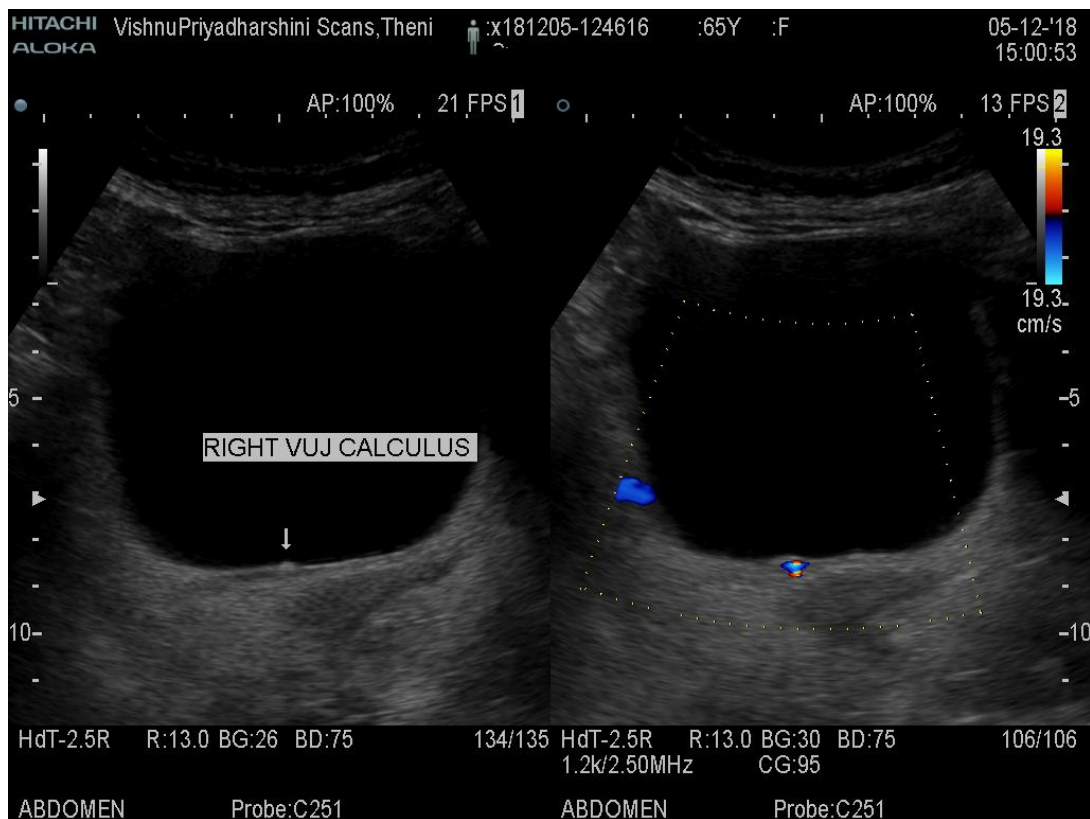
(b): The same patient with staghorn calculus also had right VUJ calculus of size 3 mm with colour Doppler showing twinkle artifact.
